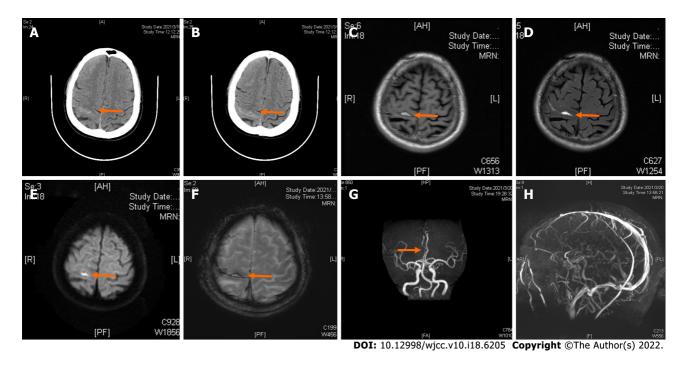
Computed tomography imaging. A and B: Axial computed tomography images showing a high-density image of right frontal-parietal sulcus; C: Magnetic resonance imaging showing slightly elevated T1-flair; D: Elevated T2-flair; E: Diffusion-weighted imaging revealed high signal intensity; F: Susceptibility weighted imaging showing slightly increased signal intensity in the right frontal; G: Machine records activity showing short local stenosis of the right anterior cerebral artery of A3 segment; H: Magnetic resonance venography revealed a thinner contrast in the left transverse sinus and left sigmoid sinus.
